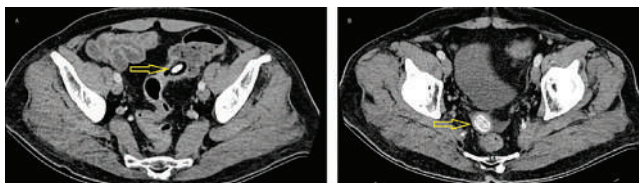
A) Contrast-enhanced abdominal CT scan shows fecalith in the sigmoid colon (arrow). B) Although not mentioned in the CT report, a calcified focus (arrow) was detected in the pelvis in the image.
